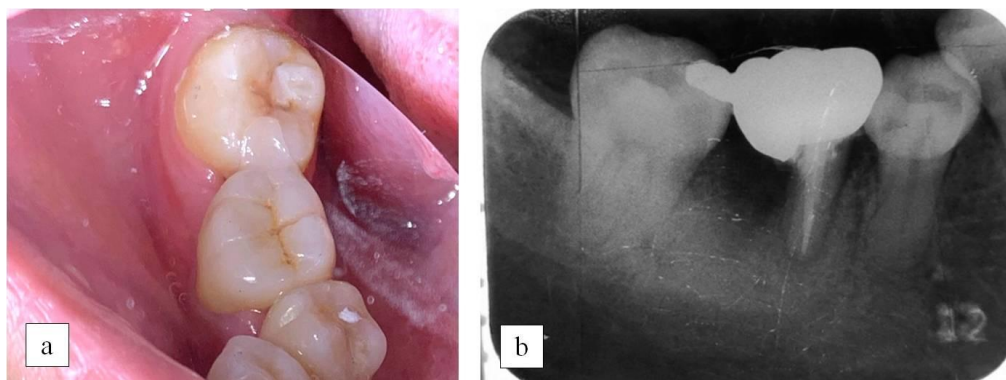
(a) Splinted zirconia crown cemented; (b) Radiographic photo taken after three months of endodontic surgery and cementation of the splinted zirconia crown.
